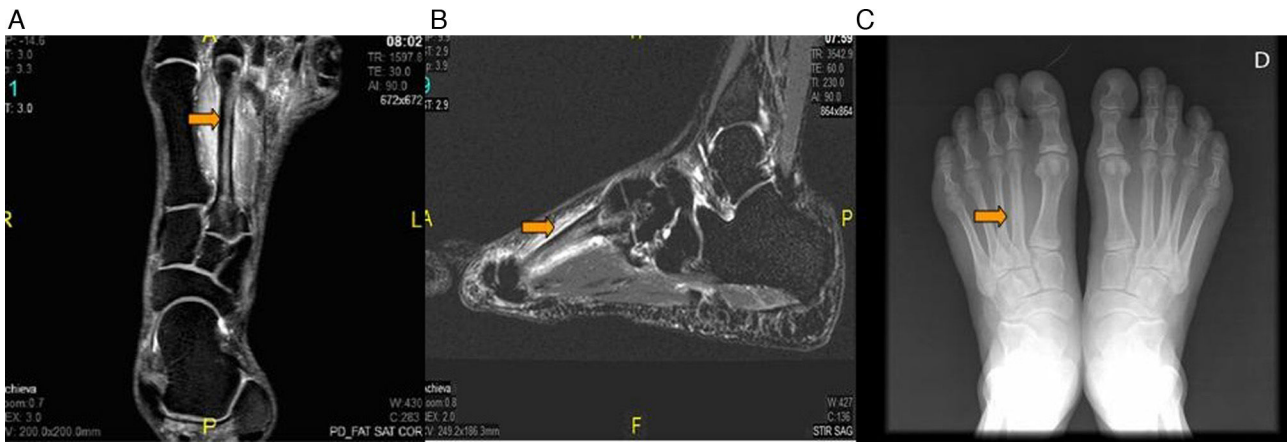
(A) Coronal magnetic resonance imaging (MRI), with fat saturation, showing bone edema in diaphysis of the second metatarsal of left foot, and in neighboring soft tissue. (B) Sagittal MRI of left foot in short tau inversion recovery (STIR) sequence showing bone edema in diaphysis of the second metatarsal, and in neighboring soft tissue. (C) Plain radiography showing the image of the fracture callus in the diaphysis of the second metatarsal of left foot.
